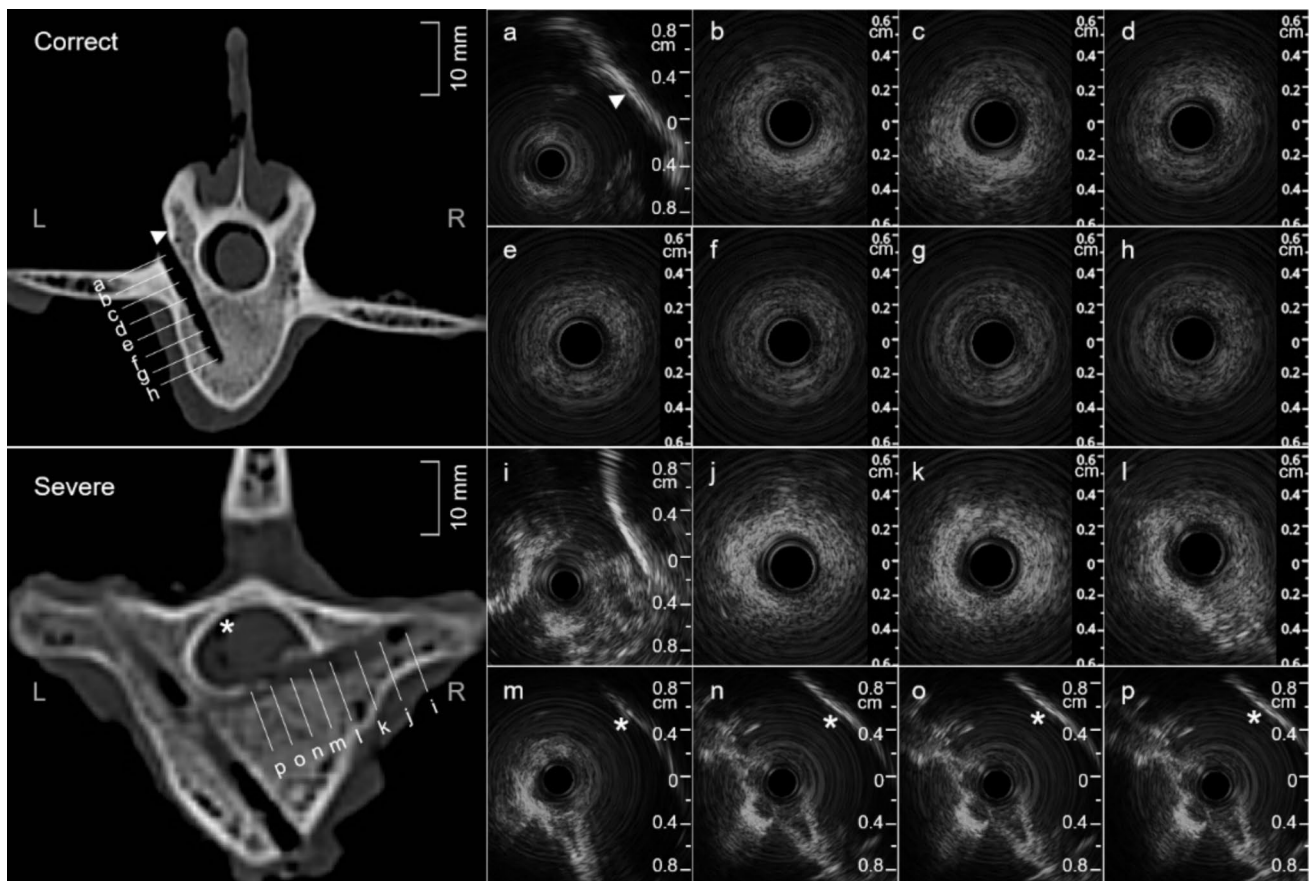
The EUS images of pedicle screw holes with correct position and severe malposition. (a) to (h) represent the ultrasound images at different depth positions from the entry-point to the bottom in the correctly positioned screw hole. The linear strong echo represents the lamina (triangle mark). (i) to (p) represent the ultrasound images
